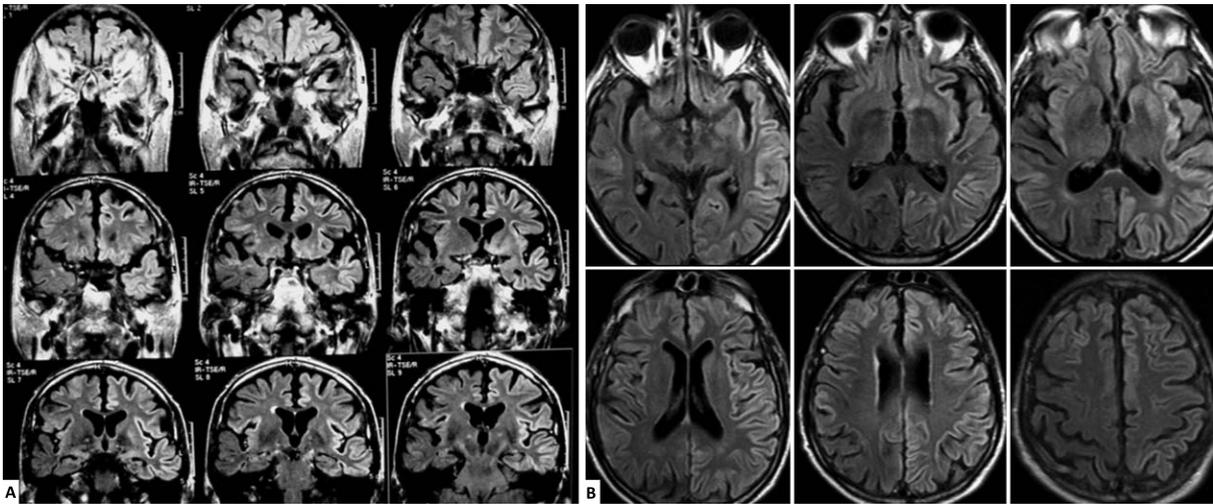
a) Initial brain MRI, on fluid-attenuated inversion recovery (FLAIR) acquisition, showing increased signal in the left cortical ribbon. Abnormal bright signal in the cortical ribbon was also observed in some areas of the right frontal, temporal, and parietal lobes. b) Follow-up brain MRI on FLAIR performed two months later. Abnormal bilateral signal brightness was found in the caudate and putamen as well as findings similar to baseline MRI.
